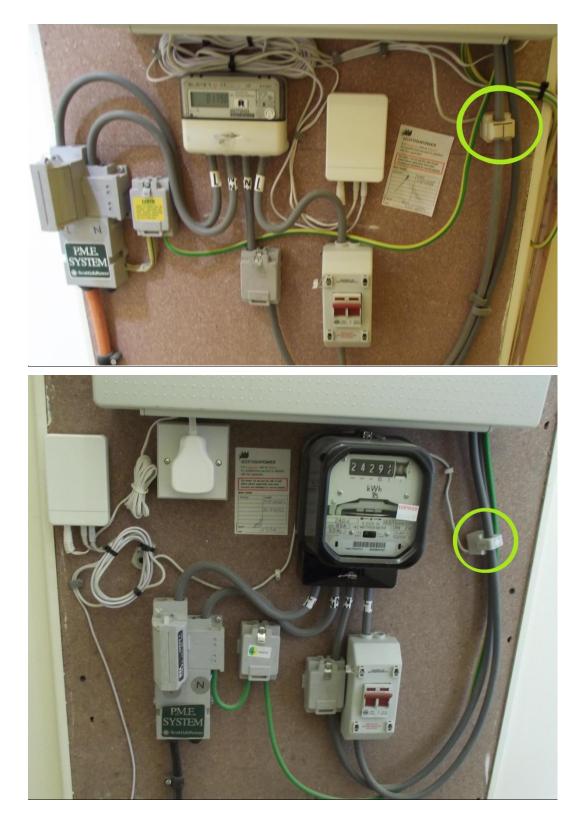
Photos of Ewgeco connection CT clip (highlighted) to electricity cables
